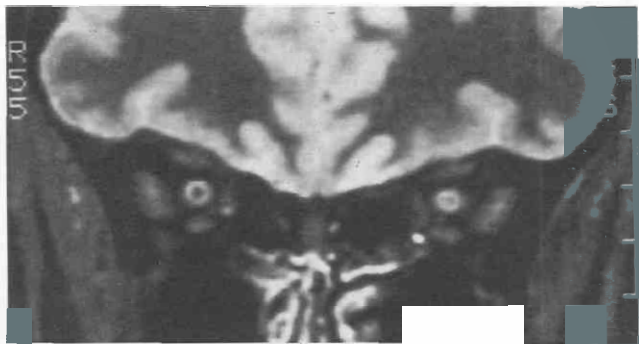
Coronal MRI study, inversion recovery fast spin echo, shows left optic neuritis with increased signal at the left optic nerve.
